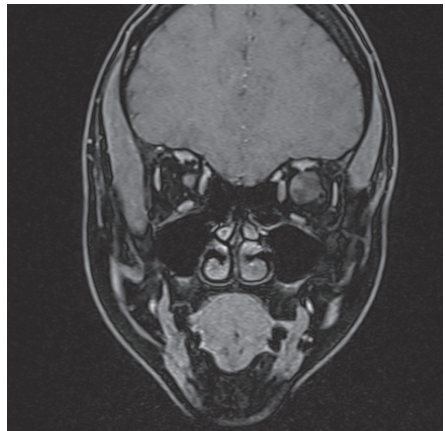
Preoperative coronal MRI scans of the patient.
